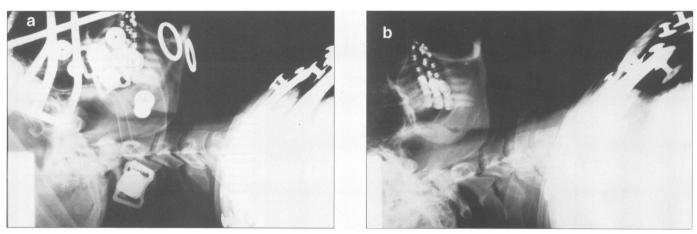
a, Lateral radiograph of the cervical spine with a football helmet and shoulder pads present. Note the neutral alignment of the cervical vertebrae. b, Lateral radiograph of the cervical spine after the football helmet has been removed. Note the increase in hyperextension (approximately 20°).
